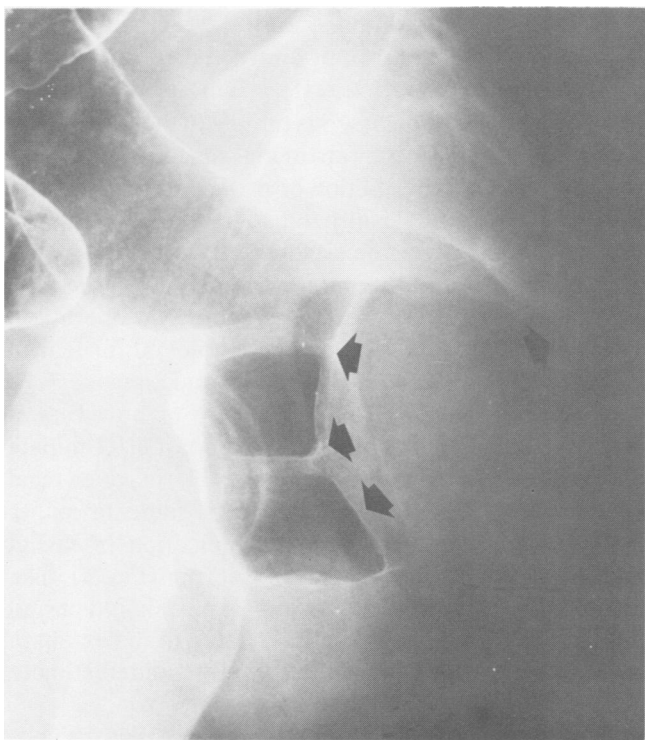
Barium air contrast x-ray study showing anterior displacement of the rectum and destruction of the sacrum by chordoma.
